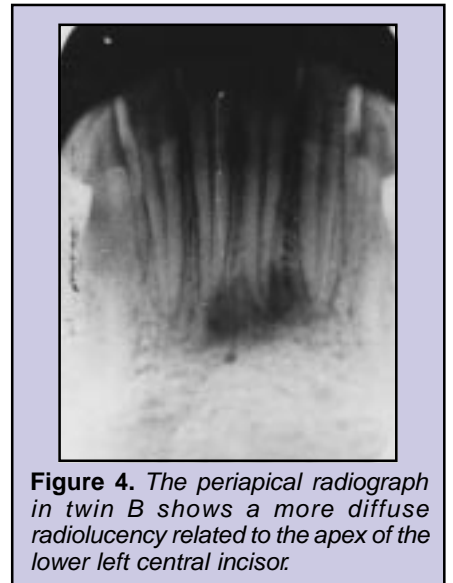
The periapical radiograph in twin B shows a more diffuse radiolucency related to the apex of the lower left central incisor.
